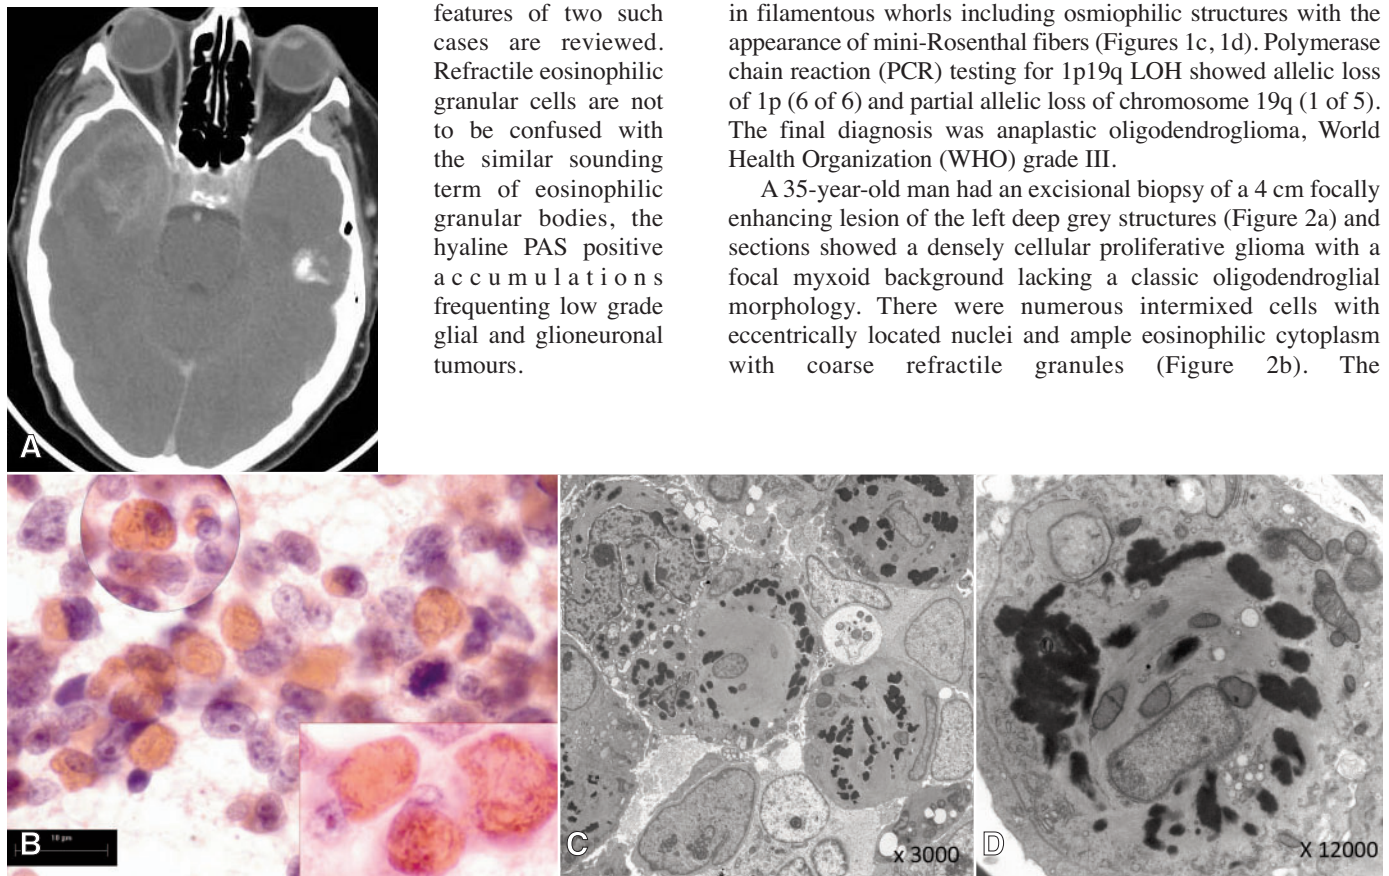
a - axial T1 contrast enhanced MRI showing ring enhancing right temporal brain tumour; b - smears prepared intra-operatively showing lesional glial cells with eosinophilic refractile cytoplasmic inclusions; c, d - ultrastructural examination (X3000 and X12000 magnification) showed the refractile eosinophilic cells to contain cytoplasmic filamentous whorls and osmiophilic structures with the appearance of mini-Rosenthal fibers.
